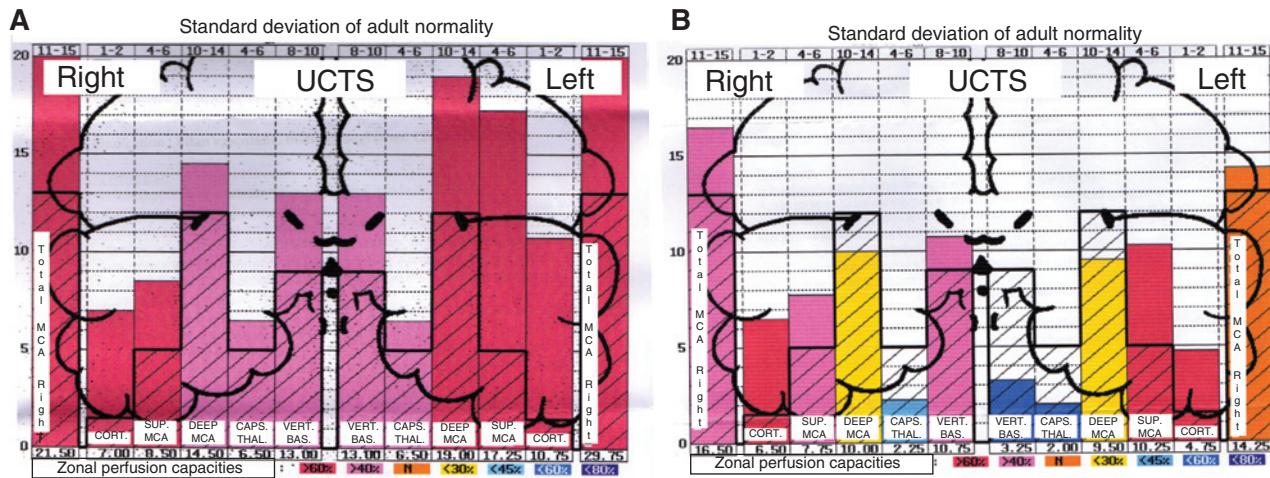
Pulsometric index (PI) obtained by a computerized ultrasonic cerebral tomosphygmography (UCTS) in the different area of temporal lobes.
